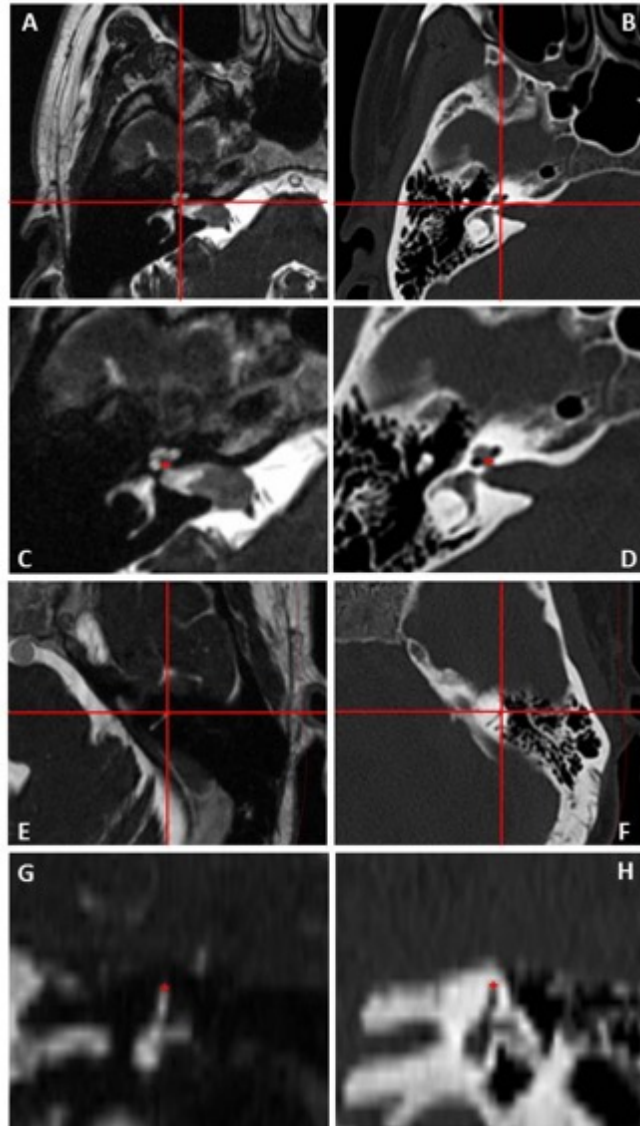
Landmarks used for frame stability evaluation. The landmarks as seen in the T2 weighted sequence of the pre-GKR MRI scan are showed in the left panel. The right panel shows the same landmarks in the bone window of the post-treatment CT scan. A-B: Right cochlear apertures are identified by the intersection of the lines. C-D: A detail shows the red cross on the landmark as measured for the study. E-F: Initial identification of the anterior post of the left superior semicircular canal in the axial plane (line intersection) and its summit as identified in the coronal plane (red cross; G-H).
